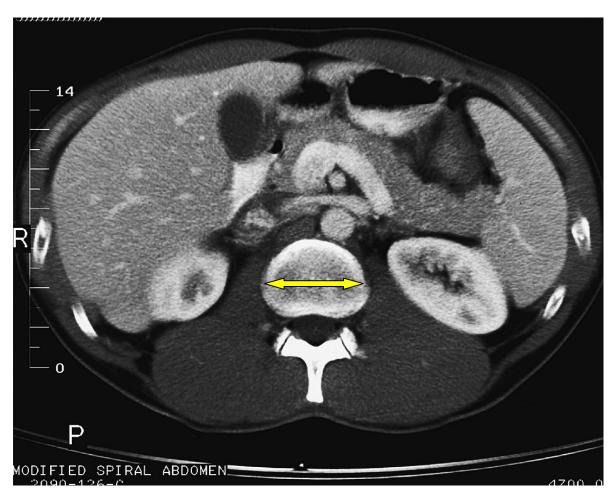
Axial CT for abdomen shows the vertebral width as reference plane (yellow arrow)
